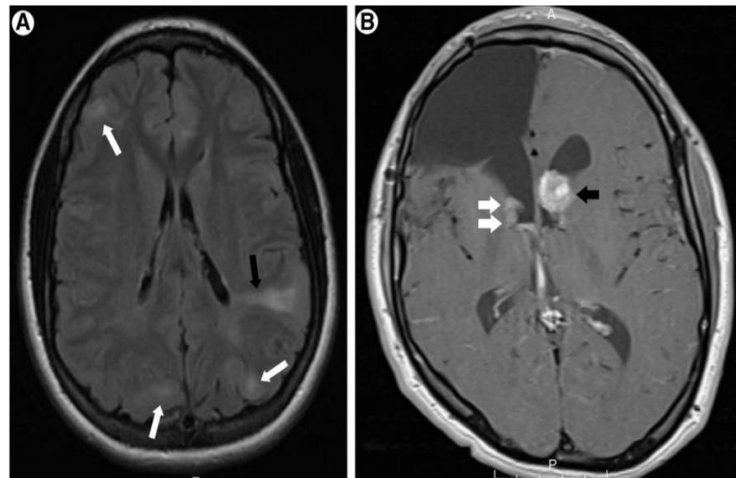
a) axial magnetic resonance imaging (MRI) T2 fluid-attenuated inversion recovery) of the brain.
